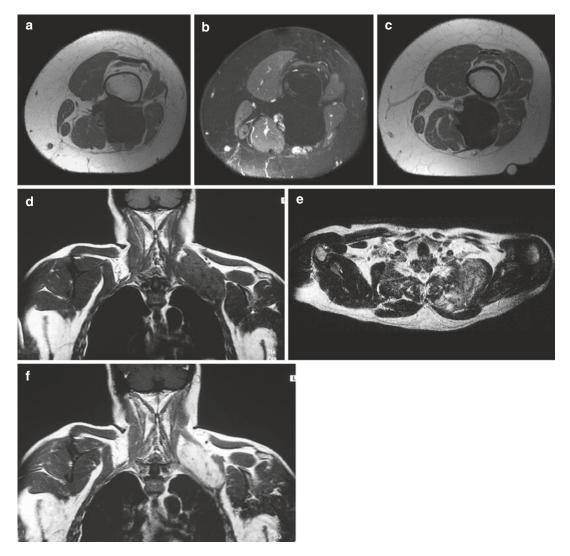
(a–f) Two cases of desmoid, one located at the hamstrings (a–c) and the other at the left serratus muscle (d–f). (a) Axial spin-echo T1-weighted MR image. (b) Axial spin-echo T2-weighted MR image with fat suppression. (c) Axial spin-echo T1-weighted MR image, after gadolinium contrast injection. (d) Coronal spin-echo T1-weighted MR image. (e) Axial turbo spinecho T2-weighted MR image with fat suppression. (f) Coronal spin-echo T1-weighted MR image after gadolinium contrast injection. The first case is an old, mature
